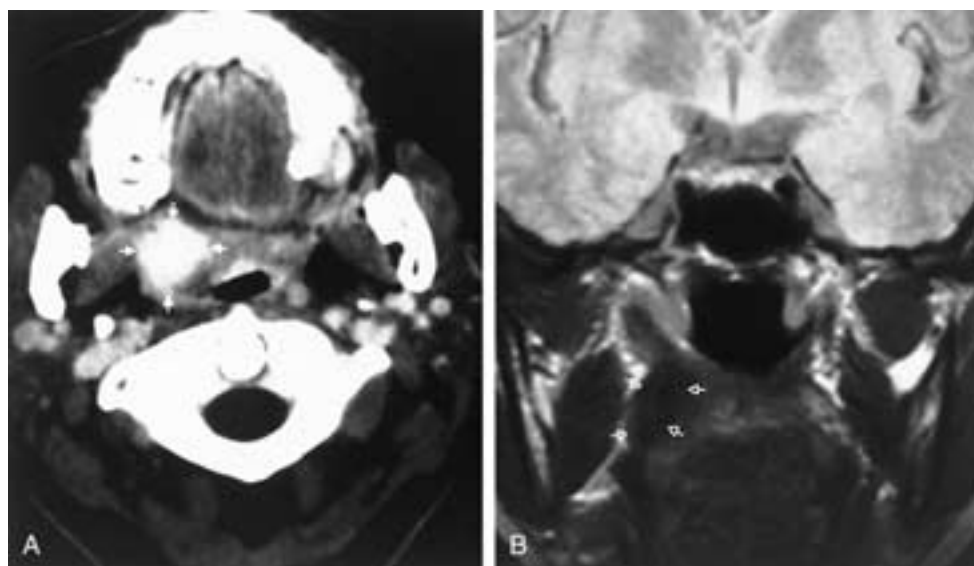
Granular cell of the right tonsillar pillar. A, Contrast-enhanced axial CT scan demonstrates an enhancing mass that involves the right tonsil (*arrows*). B, Coronal proton density MR. The mass has decreased signal intensity (*arrows*). This is typical for carcinoma. Low signal is a reflection of fibrotic elements within granular cell myoblastoma. (A and B courtesy of Dr. H. Ric Harnsberger, University of Utah.)
